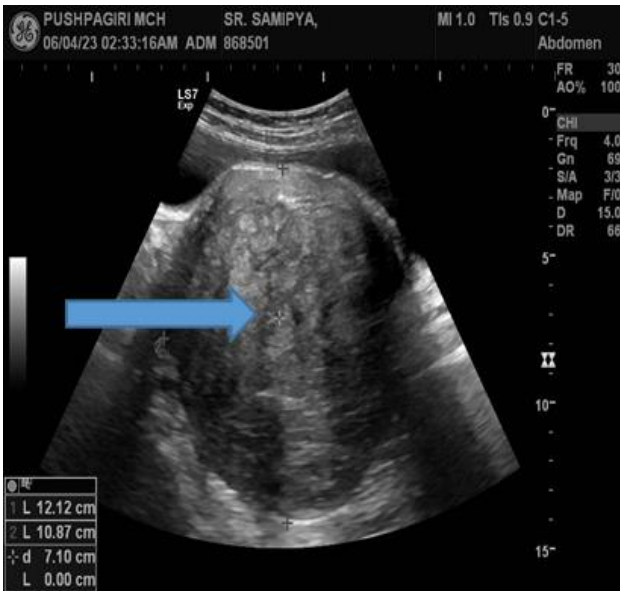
Ultra sonogram image showing large pedunculated fibroid.
